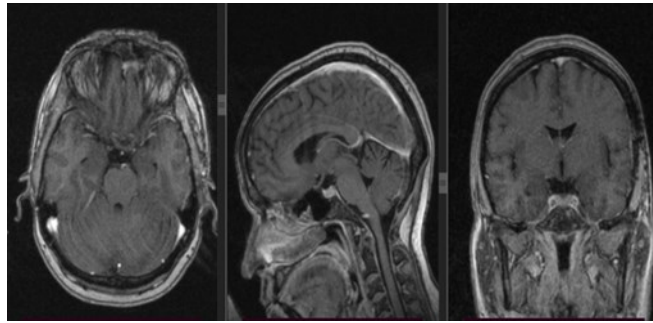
MRI of the head after treatment Shows: Surgical Bed in Tuberculum sellae noted at T1 images, where the absence of lesions is visualized.
